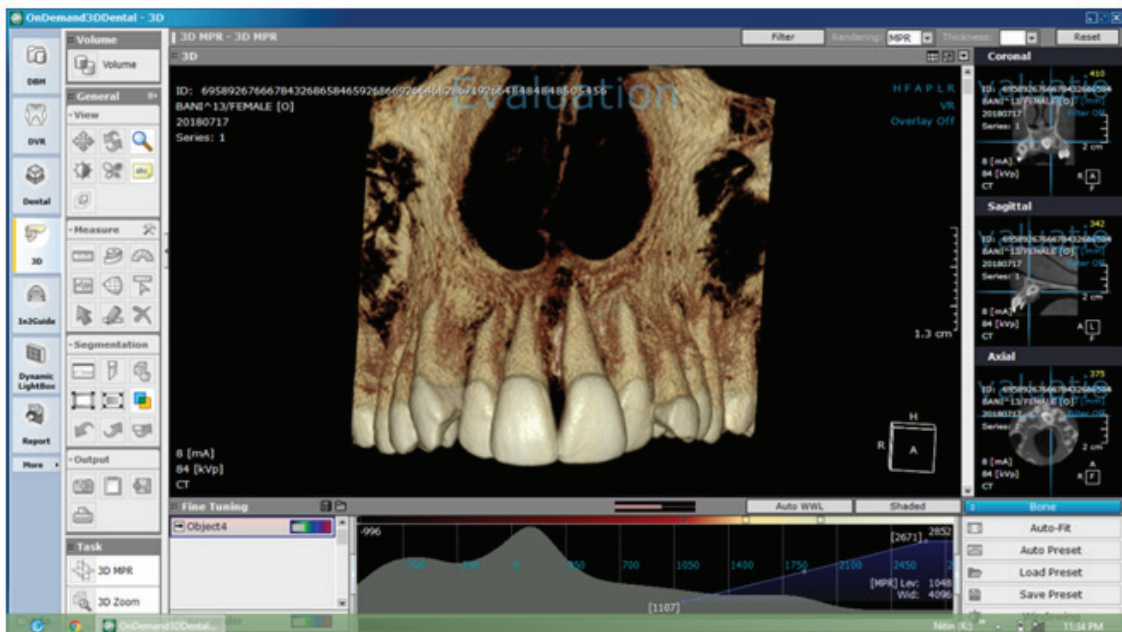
3D reconstructed CBCT image of maxilla
